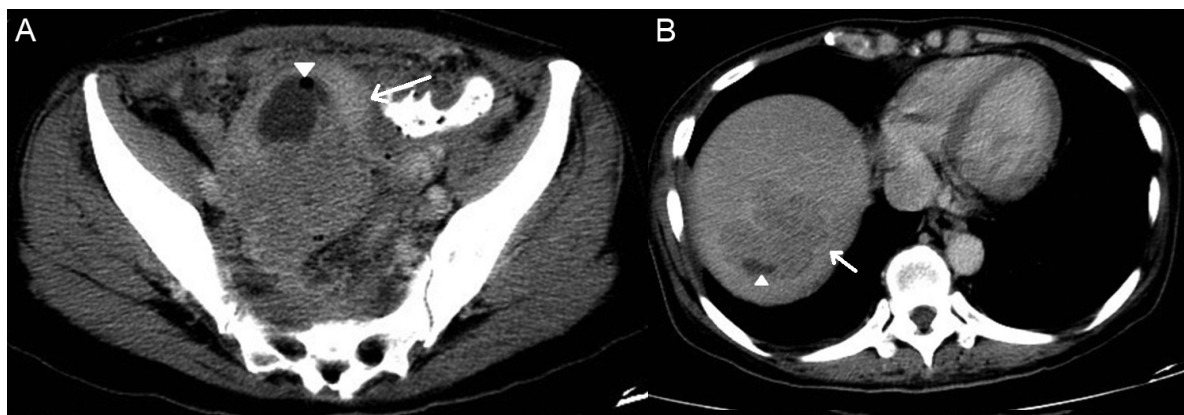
Contrast-enhanced computed tomography scan obtained after intravenous administration of 100mL of iomeprol (iohexol, 300mg of iodine/mL) showed (A) a heterogeneously enhancing soft tissue lesion (arrow) with a non-enhancing internal fluid collection and internal gas (arrowhead) in the right adnexa. (B) A mixed solid and cystic mass lesion (arrowhead) with peripheral faint contrast enhancement (arrow) in the liver dome was also appreciated.
